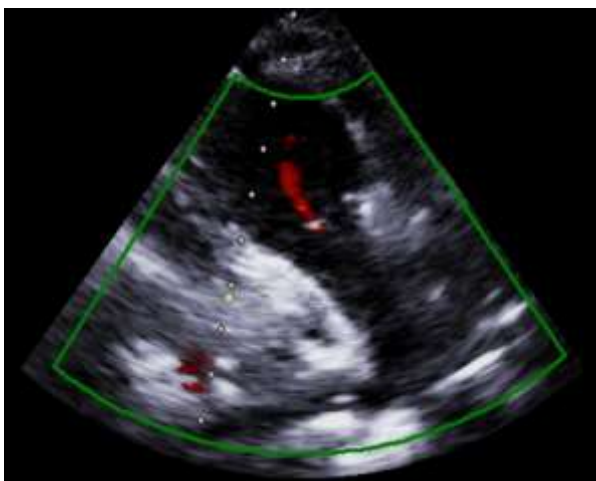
Echocardiography shows no patent ductus arteriosus (PDA)
